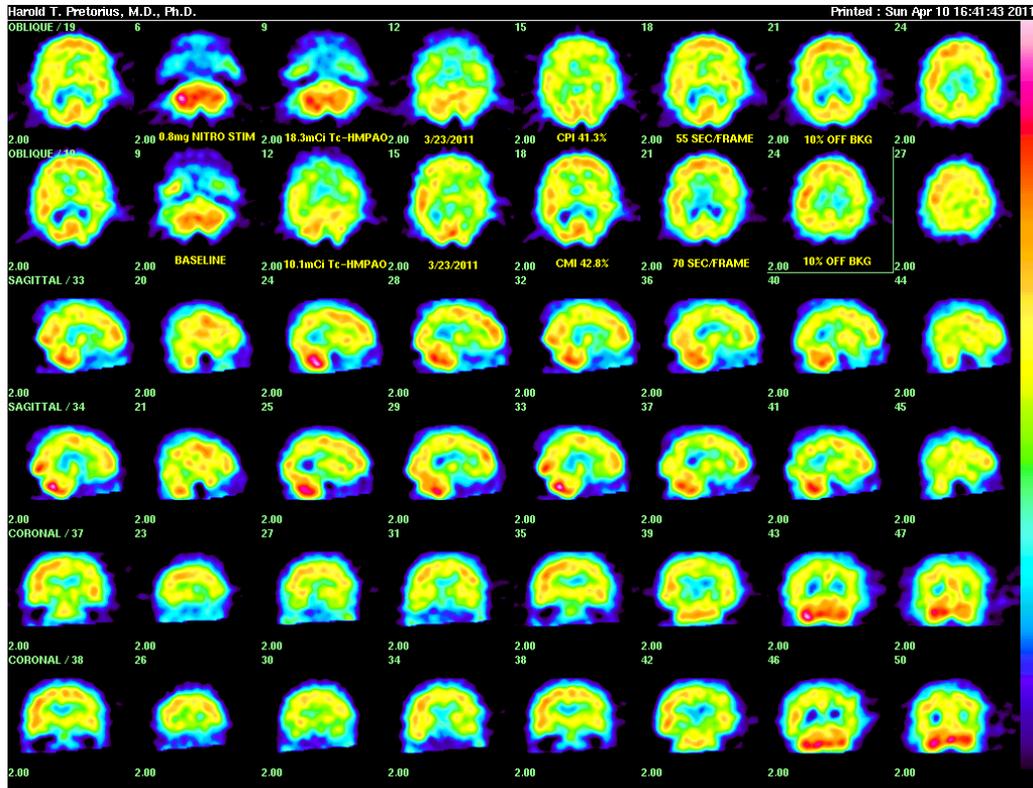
(above) Follow-up brain SPECT for the now 77.4 year old woman of Fig 4b shows compromised CMi 47.8% and CPi 41.3% with FRi -6.5% ( corrected -9.5%) after her serum creatinine increased to 2.80 mg/dl, GFR 18 ml/min and her TYM decreased to 45, consistent with progressive memory loss. A new left parietal deficit (saggital 32) and patchy temporal deficits (coronals 27-34) suggest progressive cerebrovascular disease and orbitofrontal deficits (lateral saggital images) suggest associated psychiatric depression.
